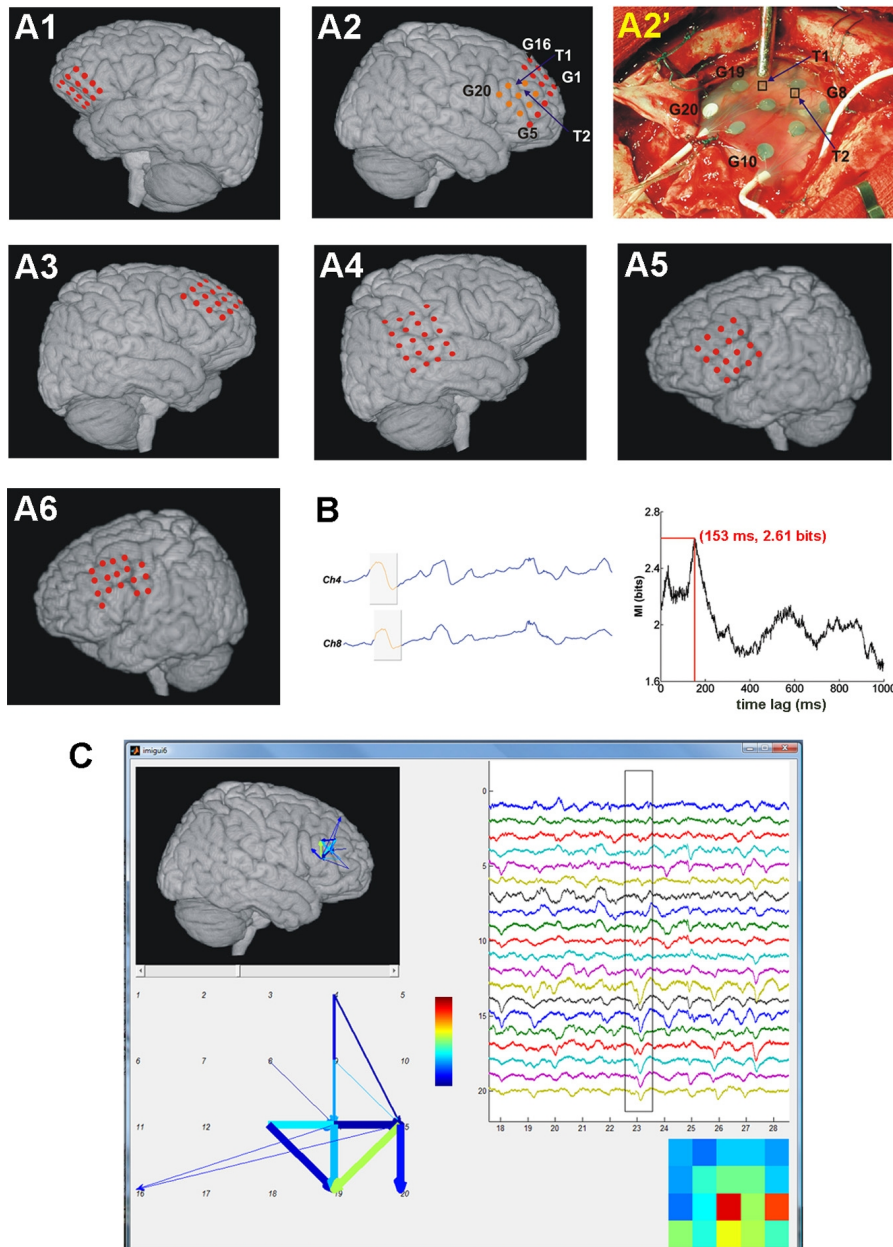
Recording and analysis of SWA propagation. *A*, Estimations of the positions of recording sites on standard human brain images based on intraoperative photographs and postoperative structural MR images (*A1–A6* correspond to Pts. 3–6, 8, 9 respectively). *A2'*, Photograph taken during the operation. Marked points and electrodes are also exhibited in the corresponding reconstruction image (*A2*). Recording sites visible in *A2'* are displayed in orange in *A2*. Channel 18 in Pt. 4 as well as channels 5, 17, and 18 in Pt. 9 were dysfunctional (i.e., either no data were recorded by the electrode, or a disproportionate amount of non-biological noise showed the malfunction of the contact site) and thus left out
